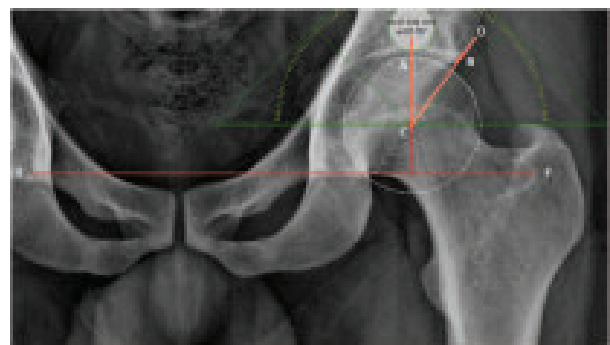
Plain digital radiograph of pelvis AP view showing measurement of center edge angle
